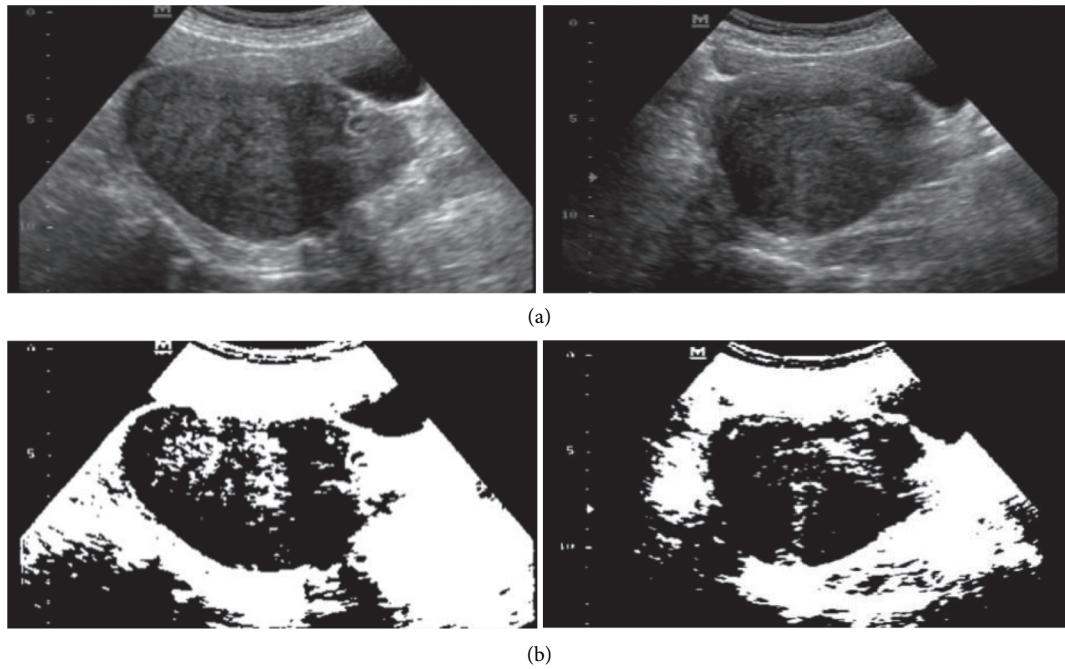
Contrast ultrasound images.
